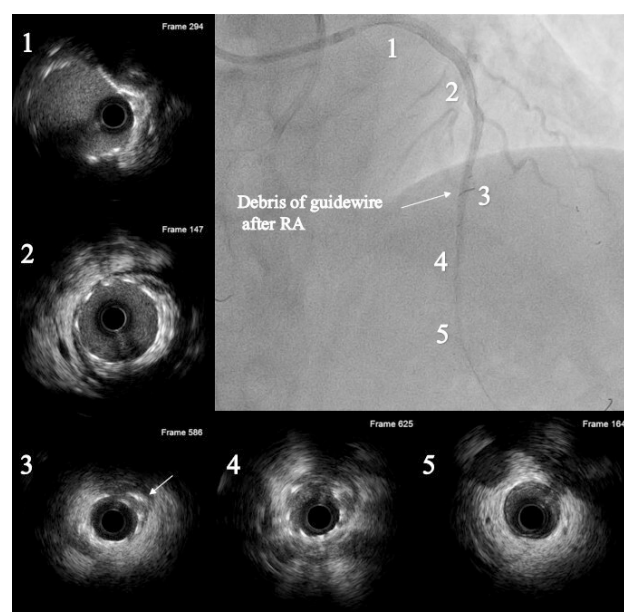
Guidewire fragments sealed by the drug-eluting stents. Final angiographic and intravascular ultrasound (IVUS) images after stents implantation. The numbers on the angiographic image coincide with the numbered IVUS position images.
